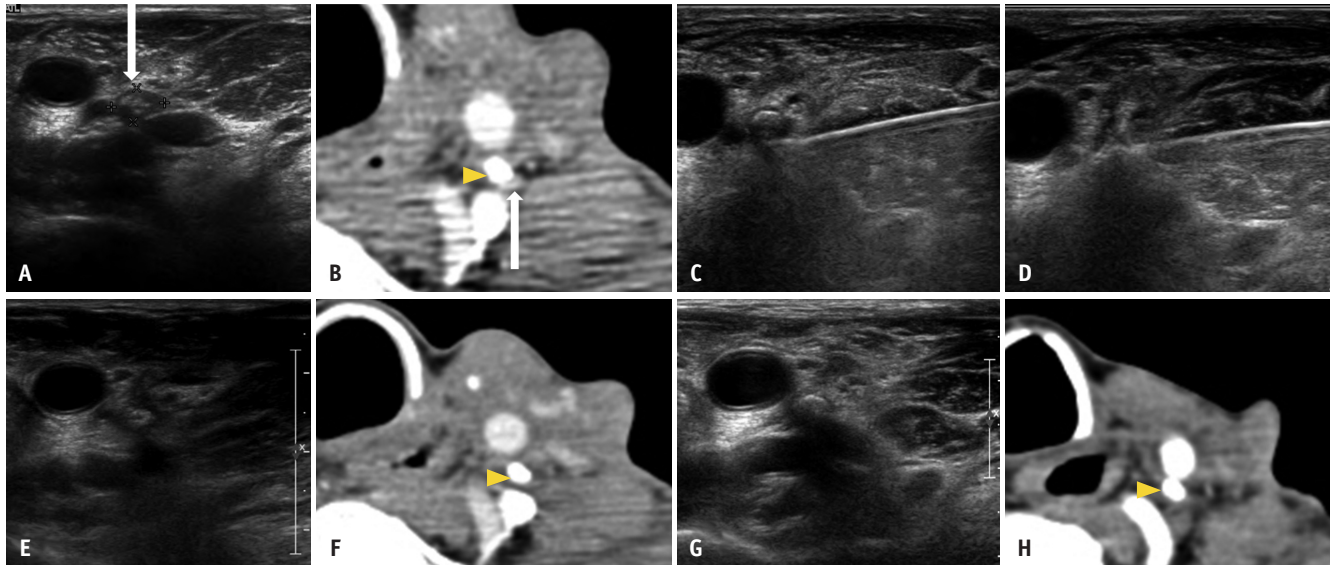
A 38-year-old male with recurrent papillary thyroid cancer at left neck level IV after thyroidectomy and RI therapy. A, B: Transverse US image shows a 0.6-cm-sized hypoechoic metastatic lymph node with macrocalcification at left neck level IV (arrow, A). The lymph node exhibits a strongly enhancing component at the posterior aspect of the calcified lymph node (arrowhead, B) on arterial-phase contrast-enhanced CT (arrow, B). C, D: An internally cooled electrode with a 0.5-cm-sized active tip is inserted into the metastatic lymph node. E, F: One month after RFA, transverse US scans (E) showed that the treated tumor had decreased in size with residual macrocalcification. On CT (F), there is no visible enhancing solid component in the posterior aspect of the calcified lymph node (arrowhead). G, H: At 120 months after RFA, the treated tumor remained macrocalcified (arrowhead, H), without a demonstrable solid component on US and CT. RI = radioactive iodine, US = ultrasound
